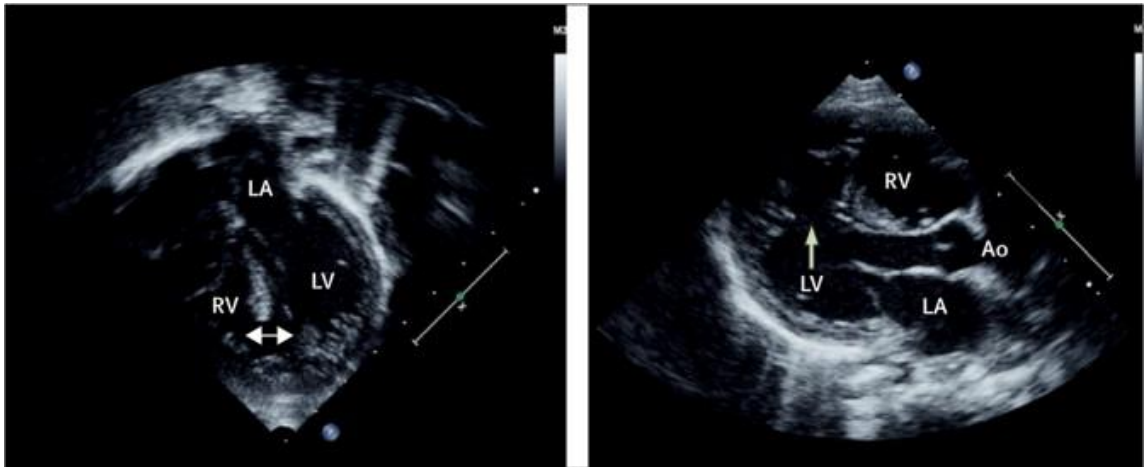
Echocardiogram of ventricular septal defect pointed by the arrows. LA is the left atrium, LV is the left ventricle, RV is the right ventricle, and Ao is the aortic valve¹¹.
